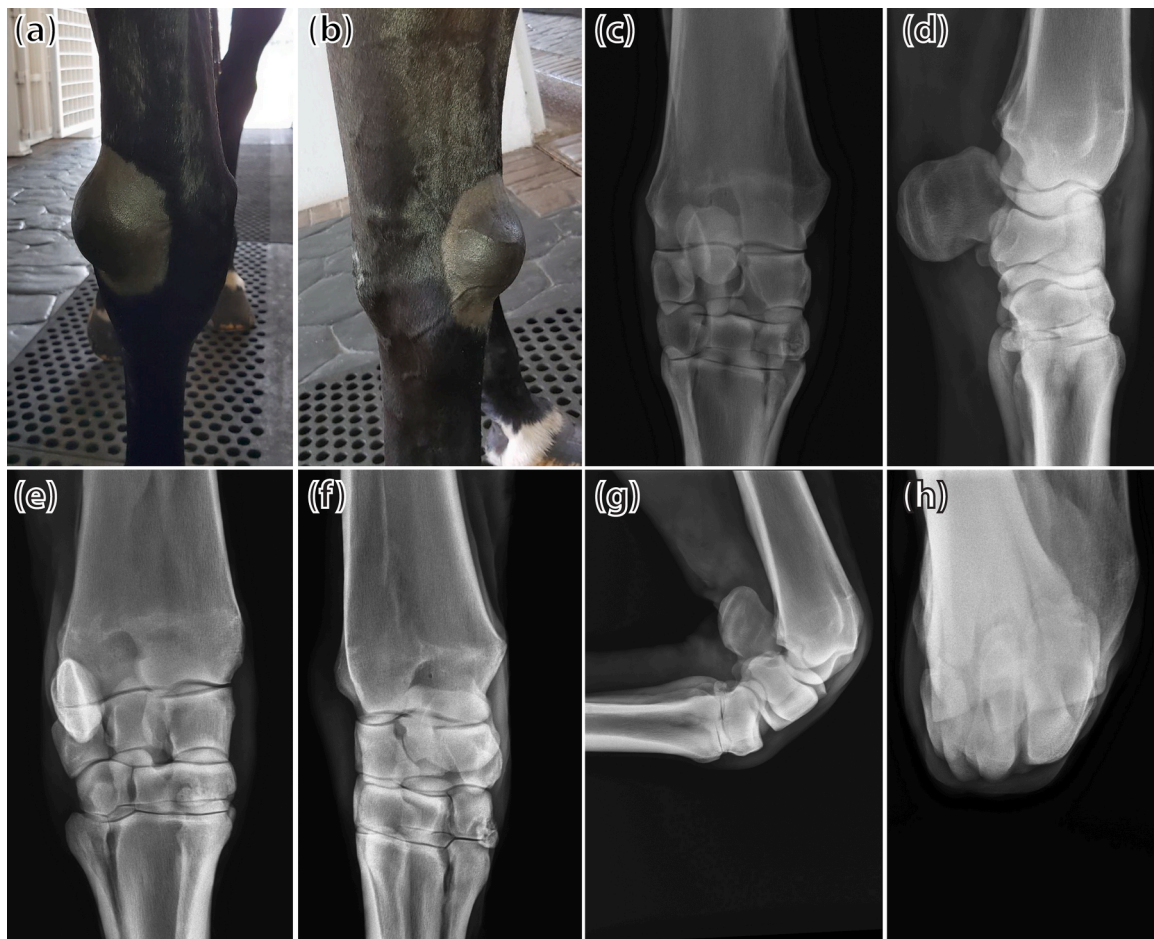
The injured area and radiographic images of the right carpus. The effusion was visible at the dorsolateral location of the right carpus (a and b). Radiographs were taken of the dorsopalmar (DPA) (c), lateromedial (LM) (d), dorsolateral-palmaromedial oblique (DL-PaMO) (e), dorsomedial-palmarolateral oblique (DM-PaLO) (f), flexed lateromedial (flex-LM) (g), and dorsoproximal-dorsodistal (skyline) (h) views. These images did not reveal any abnormalities in the carpal region.
